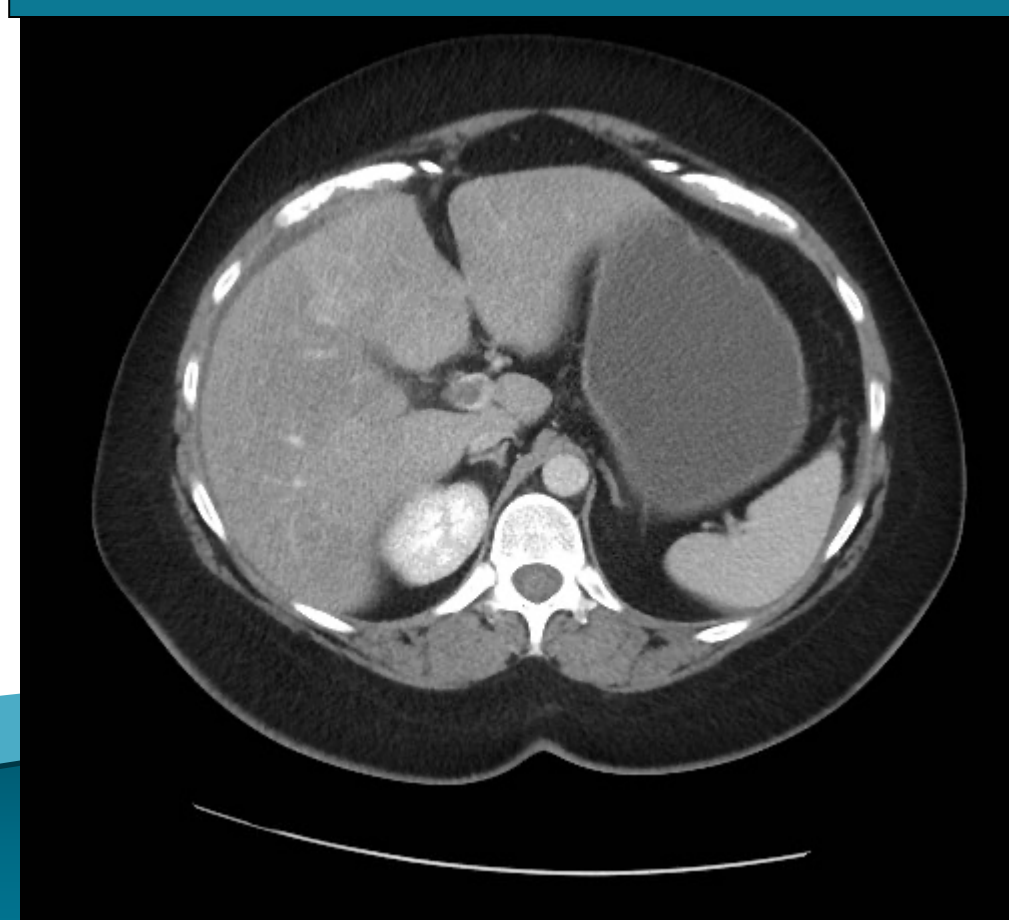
CT imaging of portal vein thrombosis
